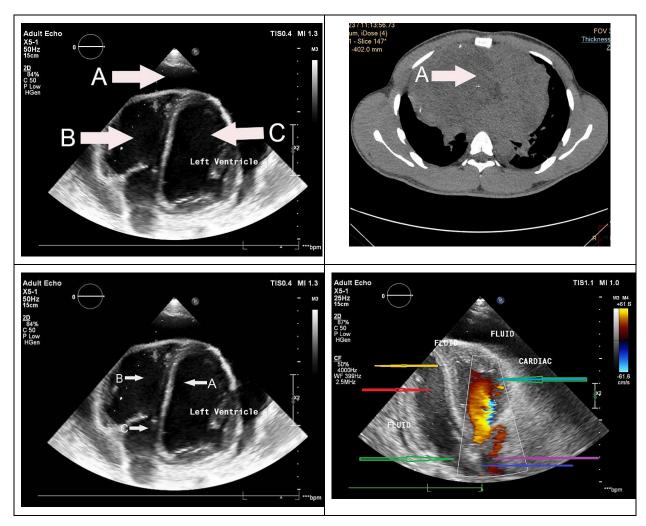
Cardiac Ultrasound found pericardial effusion (A), right ventricle (B);, and left ventricle (C). (RSPAW Radiology Department, 2023)
